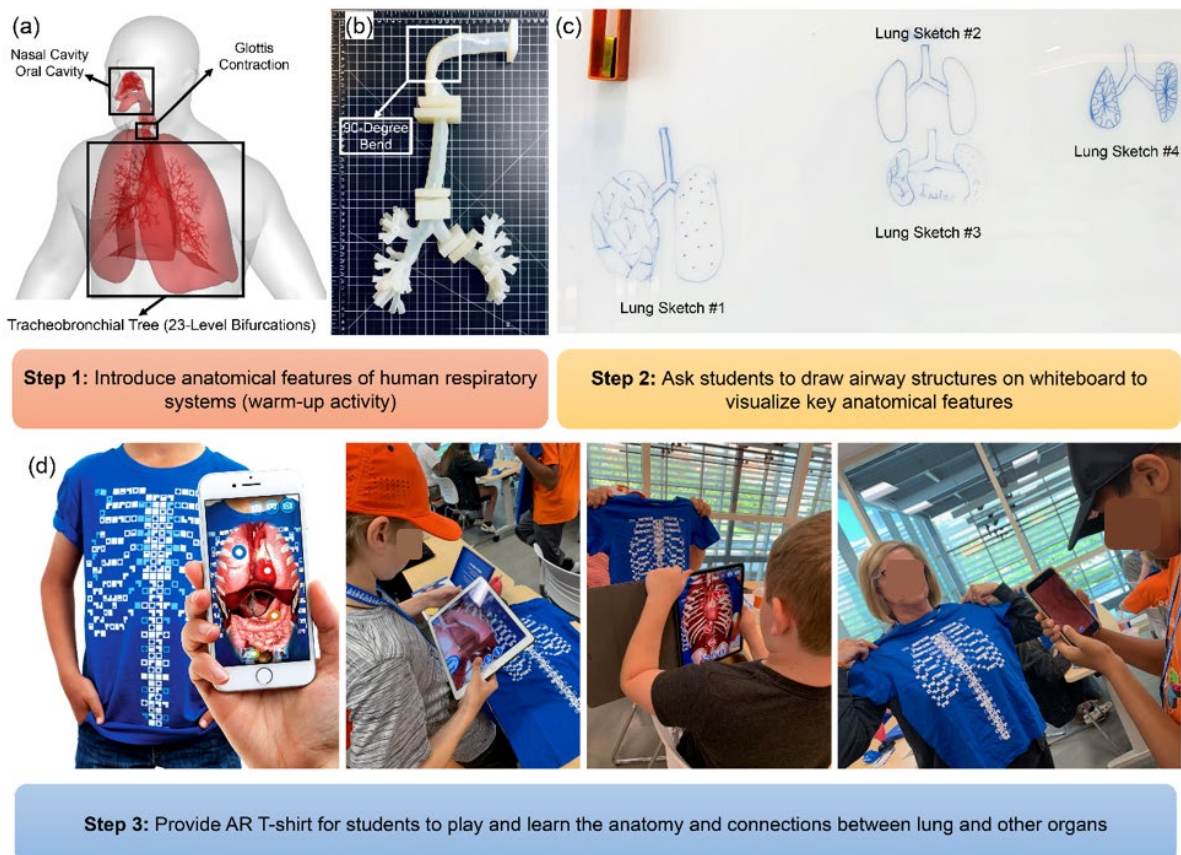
Lung Activity 1 “X-ray” test of lung structure using augmented reality (AR) T-shirt and cell-phone app. (a) Virtual lung model, (b) 3D printed human respiratory system replica, (c) sketches of human lungs drawn by students, and (d) AR T-shirt and lung tissue visualization using a cell phone app.
